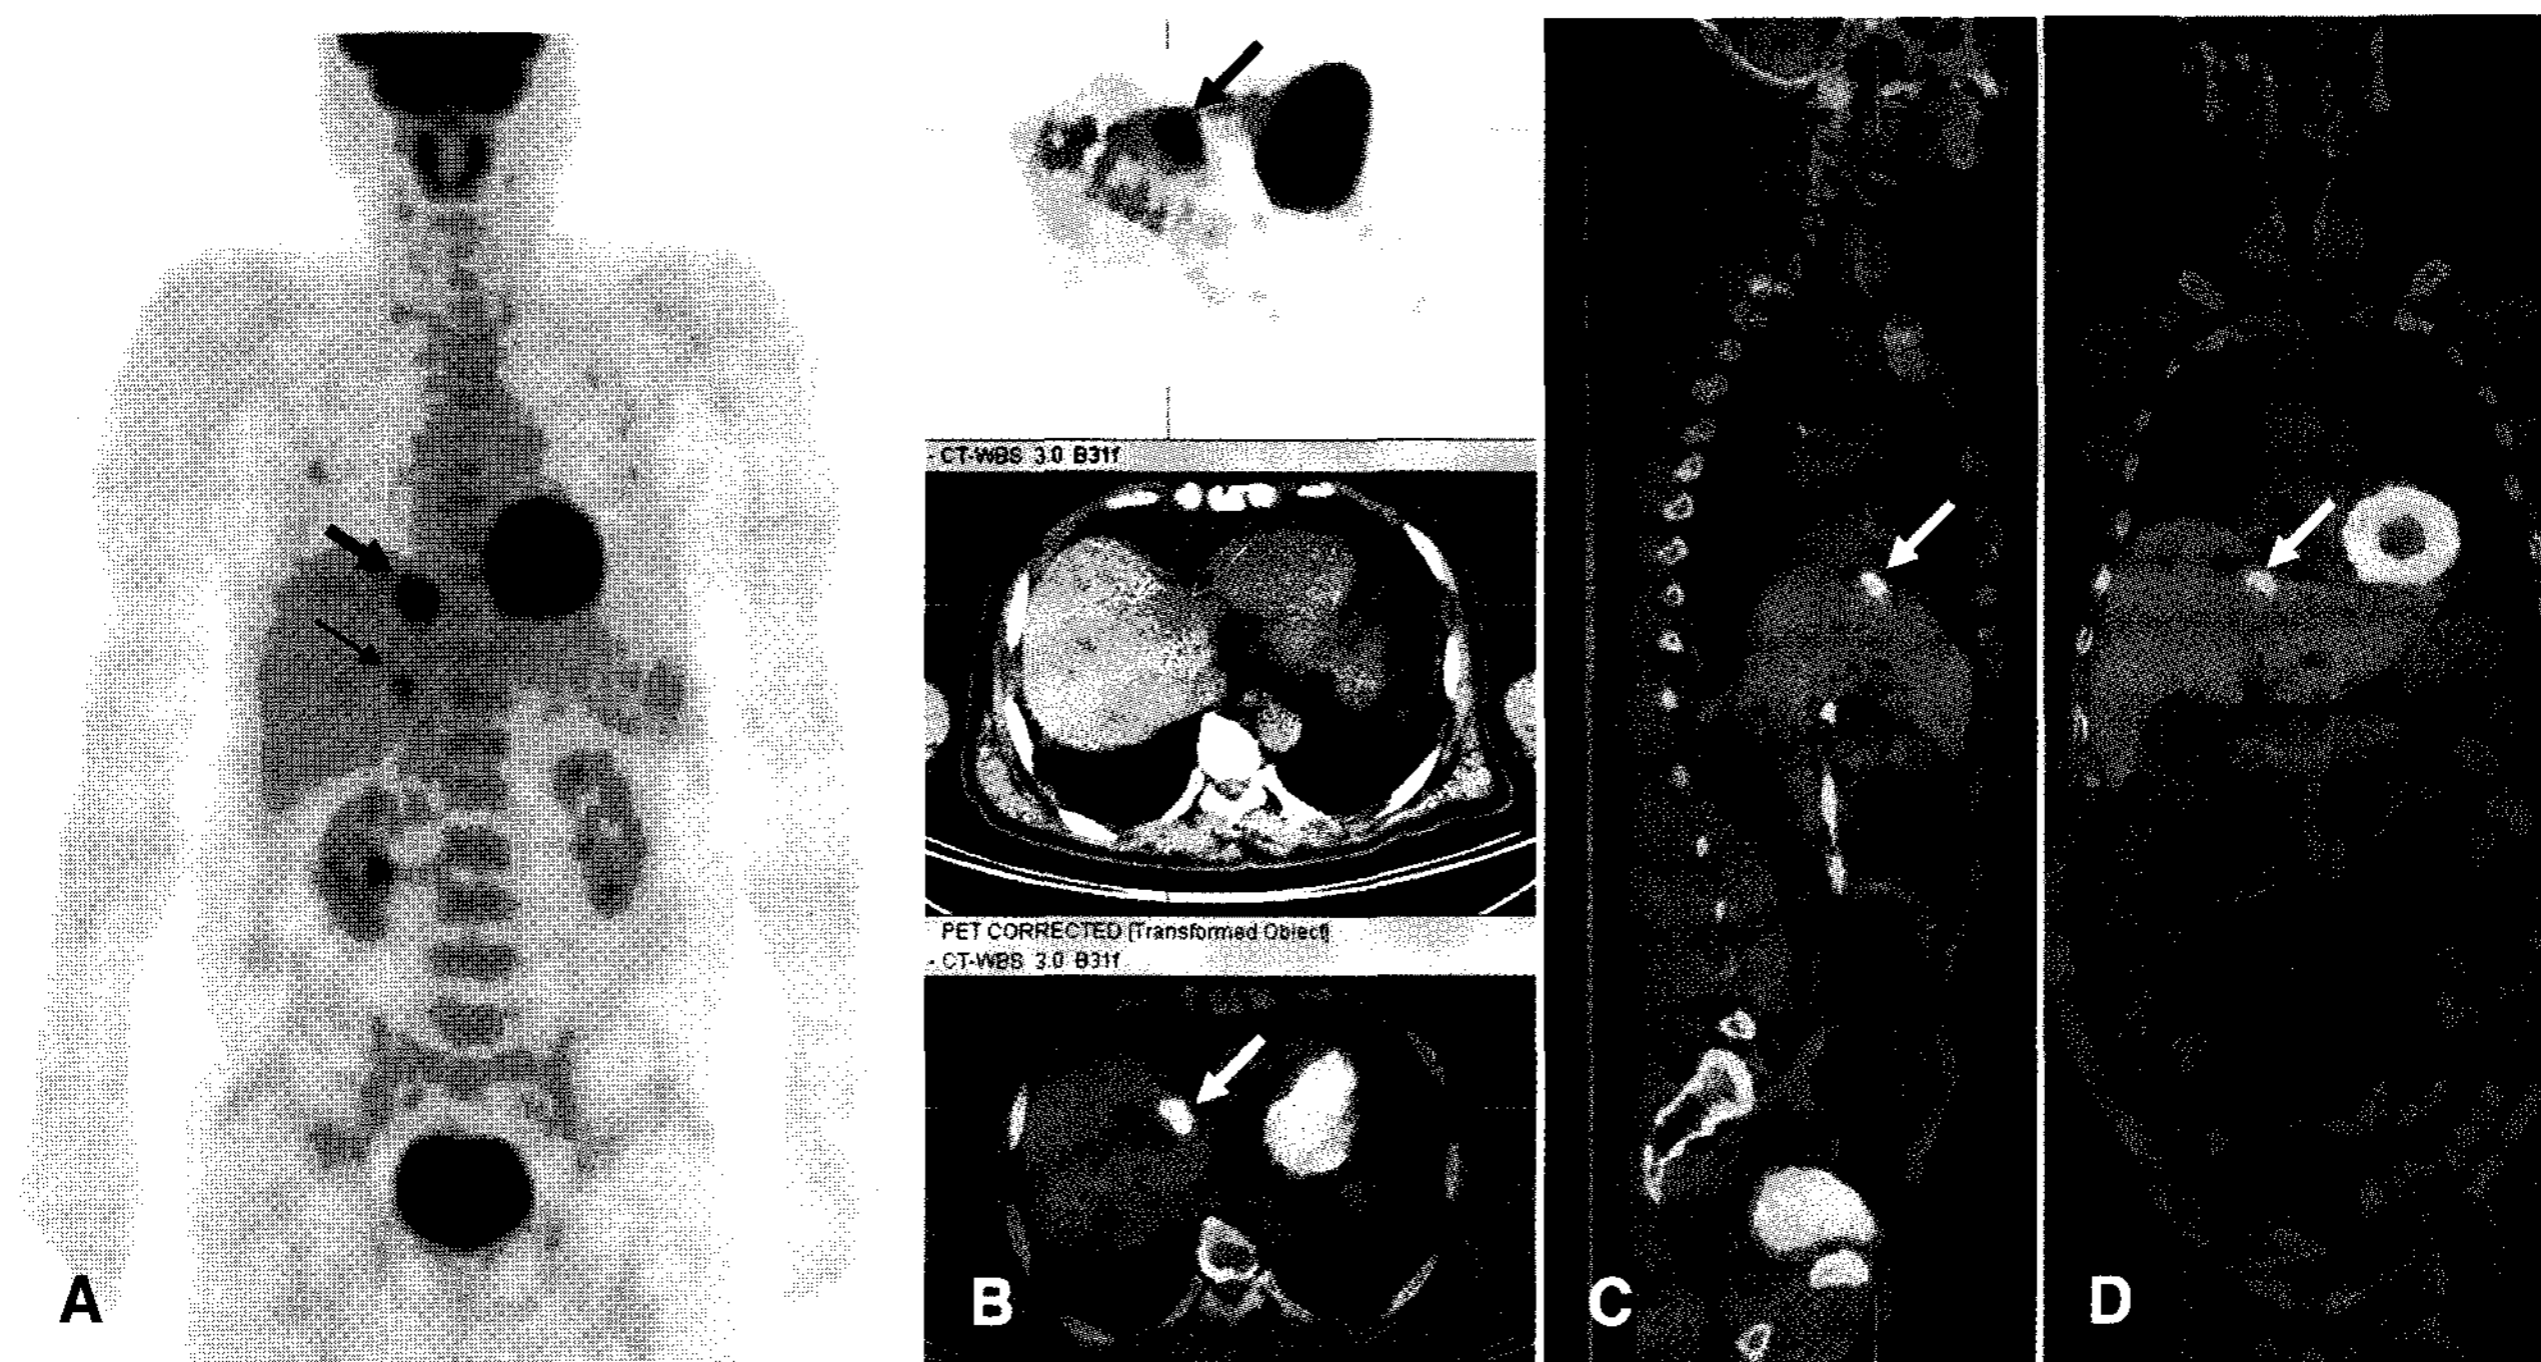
A 61-year-old man had a F-18 FDG PET/CT scan for evaluation of a common bile duct cancer. (A) The maximum-intensity-projection image demonstrated a focal hypermetabolic mass in the common bile duct (thin arrow) and an additional hypermetabolic lesion in the liver (thick arrow). (B) Transverse (upper panel, PET images; middle panel, non-enhanced CT; lower panel, PET/CT combined images), (C) sagittal, and (D) coronal images showed a focal area of hypermetabolism in segment IV of the liver (size, 3 x 2 cm; mSUV, 8.73 (black and white arrows)), corresponding to the hypoattenuated lesion (open arrow) on the non-enhanced CT scan that was consistent with metastatic disease. The patient underwent choledochojejunostomy with hepatic resection; the pathologic findings revealed adenocarcinoma in the bile duct and an eosinophilic liver abscess without cancer cells. Laboratory examination showed peripheral blood eosinophilia (4,640 WBC/ μ l with 21.1% eosinophils). The total serum IgE level was elevated (307.4 IU/ml)
